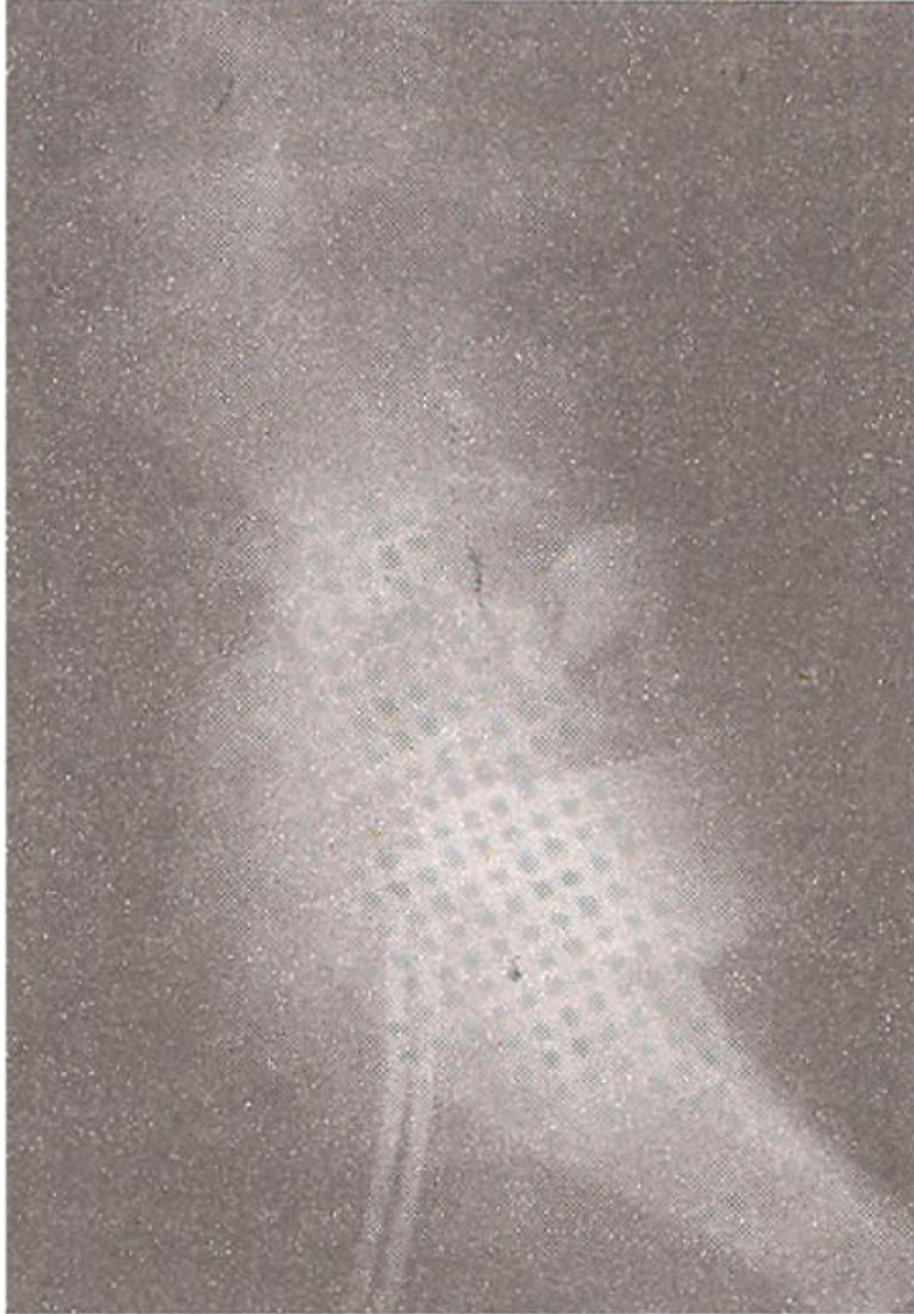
Lateral view X-ray of the pelvis taken after instilling the contrast medium in the uterus through the cervix. The medium can be seen in the bladder
